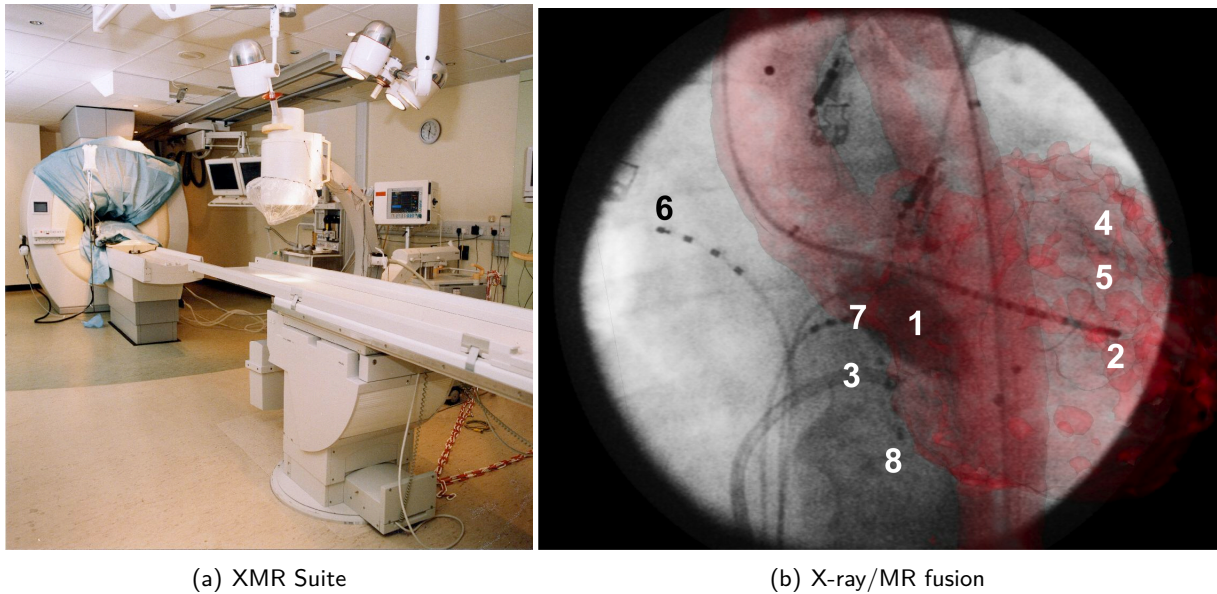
(a) XMR suite with the MR scanner and the X-ray C-arm. (b) Real-time overlay of MRI-derived left ventricular (LV) surface model (red) onto live X-ray fluoroscopy image (grey scale) to guide the placement of catheters: (1) St. Jude Ensite balloon, (2) LV roving, (3) coronary sinus sheath, (4) coronary venous/epicardial, (5) pressure, (6) high right atrium, (7) His bundle, (8) right ventricle.
